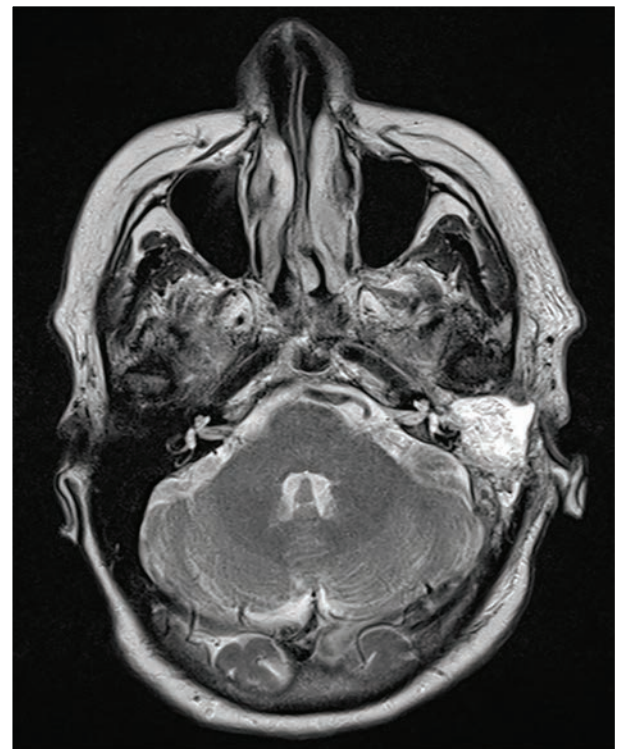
MRI of the brain and soft tissues of the neck, T2-VI with signal suppression from adipose tissue, in the coronal plane. Type C paraganglioma: postsurgical control 6 months after surgical treatment: no data for tumor recurrence
